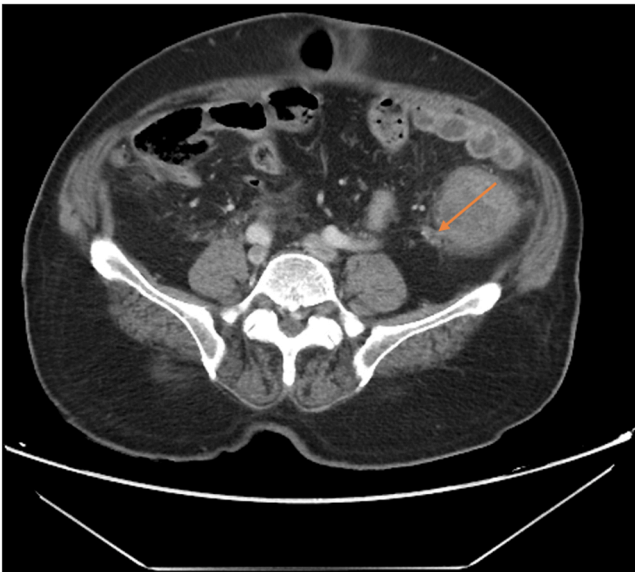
Enhanced Axial CT scan of Abdomen & Pelvis showed thickening of the descending colon with sub-colonic abscess (orange arrow).
